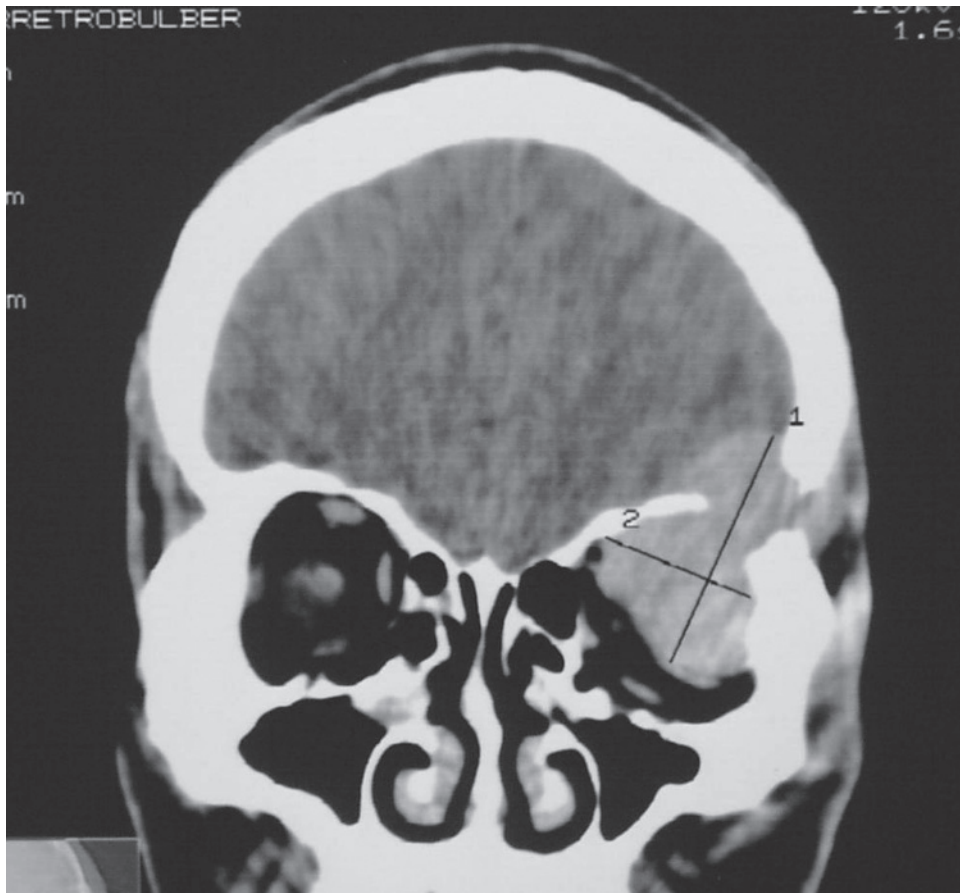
Coronal CT scan showing an osteolytic, well demarcated tumor with homogenous contrast enhancement in superolateral part of the right orbit
